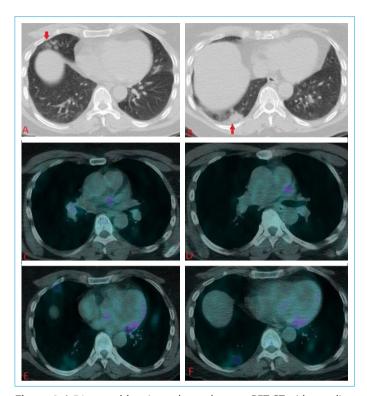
A 54-year-old patient who underwent PET CT with a preliminary diagnosis of mediastinal LAP and neoplasia, and viral pneumonia was considered on PET CT. CT shows bilateral, ground-glass infiltrates and focal consolidation predominantly peripheral and localized in the right medial lobes (a) and lower lob (b) (arrows). PET CT shows increased [¹⁸F]FDG uptake in mediastinal nodes (c), hilar nodes (d) and lung parancimal (e,f).(SUV max 5.2)
